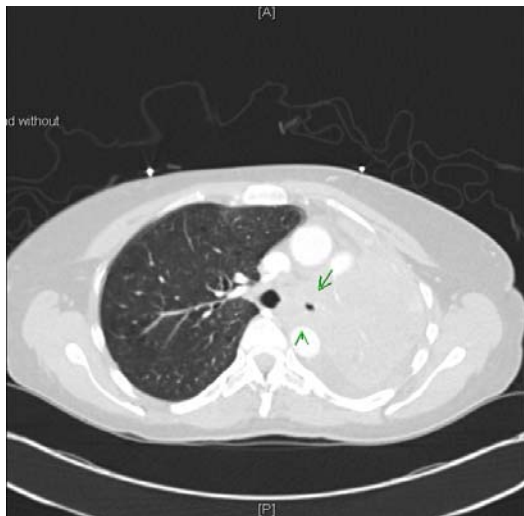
CT scan of chest showing total opacification of the left lung and a large central mass surrounding the left mainstem bronchus
